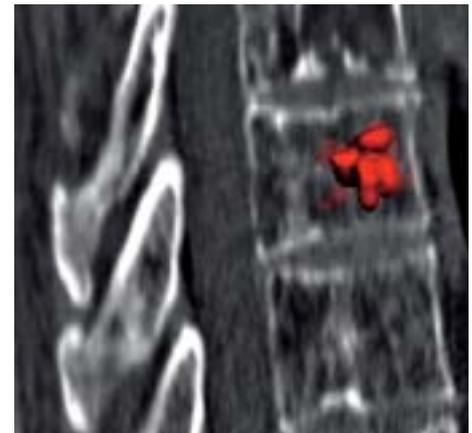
Image fusion of the segmented 3D-RA dataset and pre-interventional obtained CT (MPR sagittal reconstruction) demonstrates cement distribution overlaid with the bony structures.
